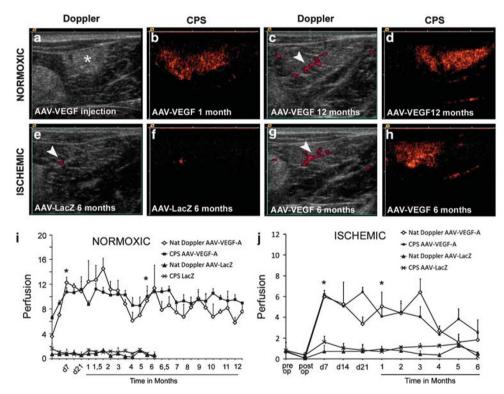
Muscle perfusion imaged by contrast pulse sequence (CPS) ultrasound technique in normal muscles (a–d) and after ischemia operation (e–h). Native image after AAV-VEGF-A-A $_{165}$  injection, asterisk indicates the location of the injection (a). CPS images from the same muscle 1 month (b) and 12 months (d) after AAV-VEGF-A-A $_{165}$  gene transfer. Power Doppler image after AAV-VEGF-A-A $_{165}$  gene transfer (c). Power Doppler (e) and CPS (f) images 6 months after ischemia operation and AAV-LacZ gene transfer. Power Doppler (g) and CPS (h) images 6 months after ischemia operation and AAV-VEGF-A-A $_{165}$  gene transfer. Arrowheads in Doppler images indicate the signal from large vessels. Perfusion ratio to contralateral intact in normal muscles (i) and in ischemic muscles (j). Perfusion in VEGF-A-transduced muscle was increased compared with LacZ muscle already 1 week after gene transfer both in normoxic and in ischemic muscles. Results are presented as means  $\pm$  s.e.m., \* $P \le 0.05$ , n = 3.
